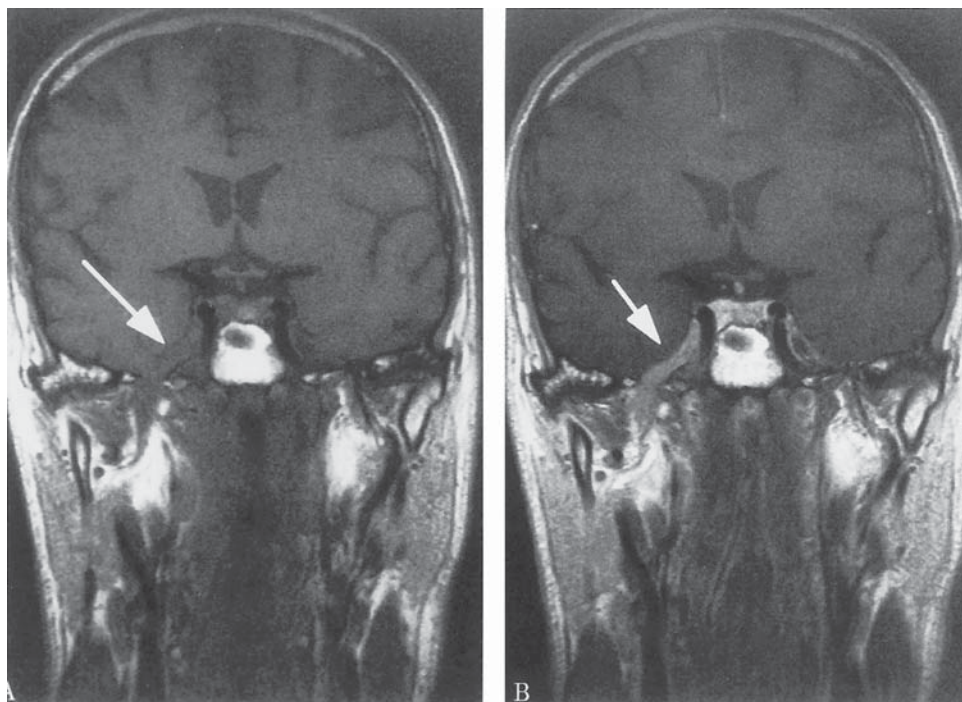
This 37-yr-old female was previously treated with surgery and radiation for adenoid cystic carcinoma of the right maxilla. Six years later she presented with neuropathic pain in the right V2 distribution. Coronal T1-weighted spin echo image before (A) and after (B) gadolinium administration demonstrate enhancement of the mandibular trigeminal nerve within the oval foramen (arrow). Adapted with permission from ref. 45.
